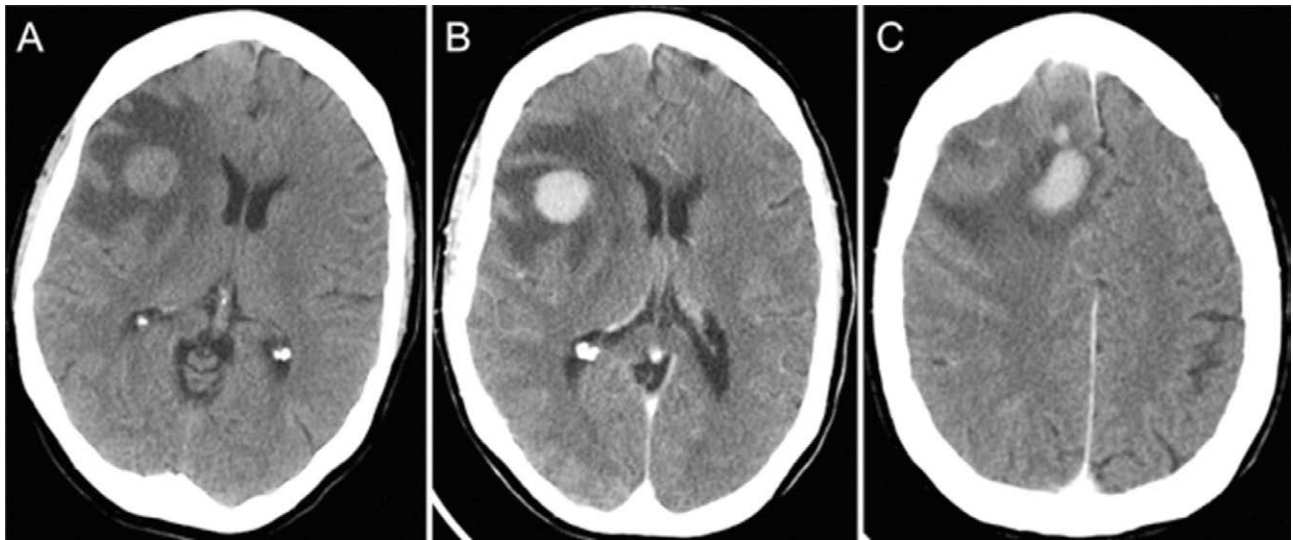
Computed tomography scan shows several right frontal mass lesions that are hyperdense prior to (A) and homogeneously enhancing after administration of contrast dye (B and C). The masses are surrounded by a hypodense area with finger-like protrusions consistent with vasogenic edema.
